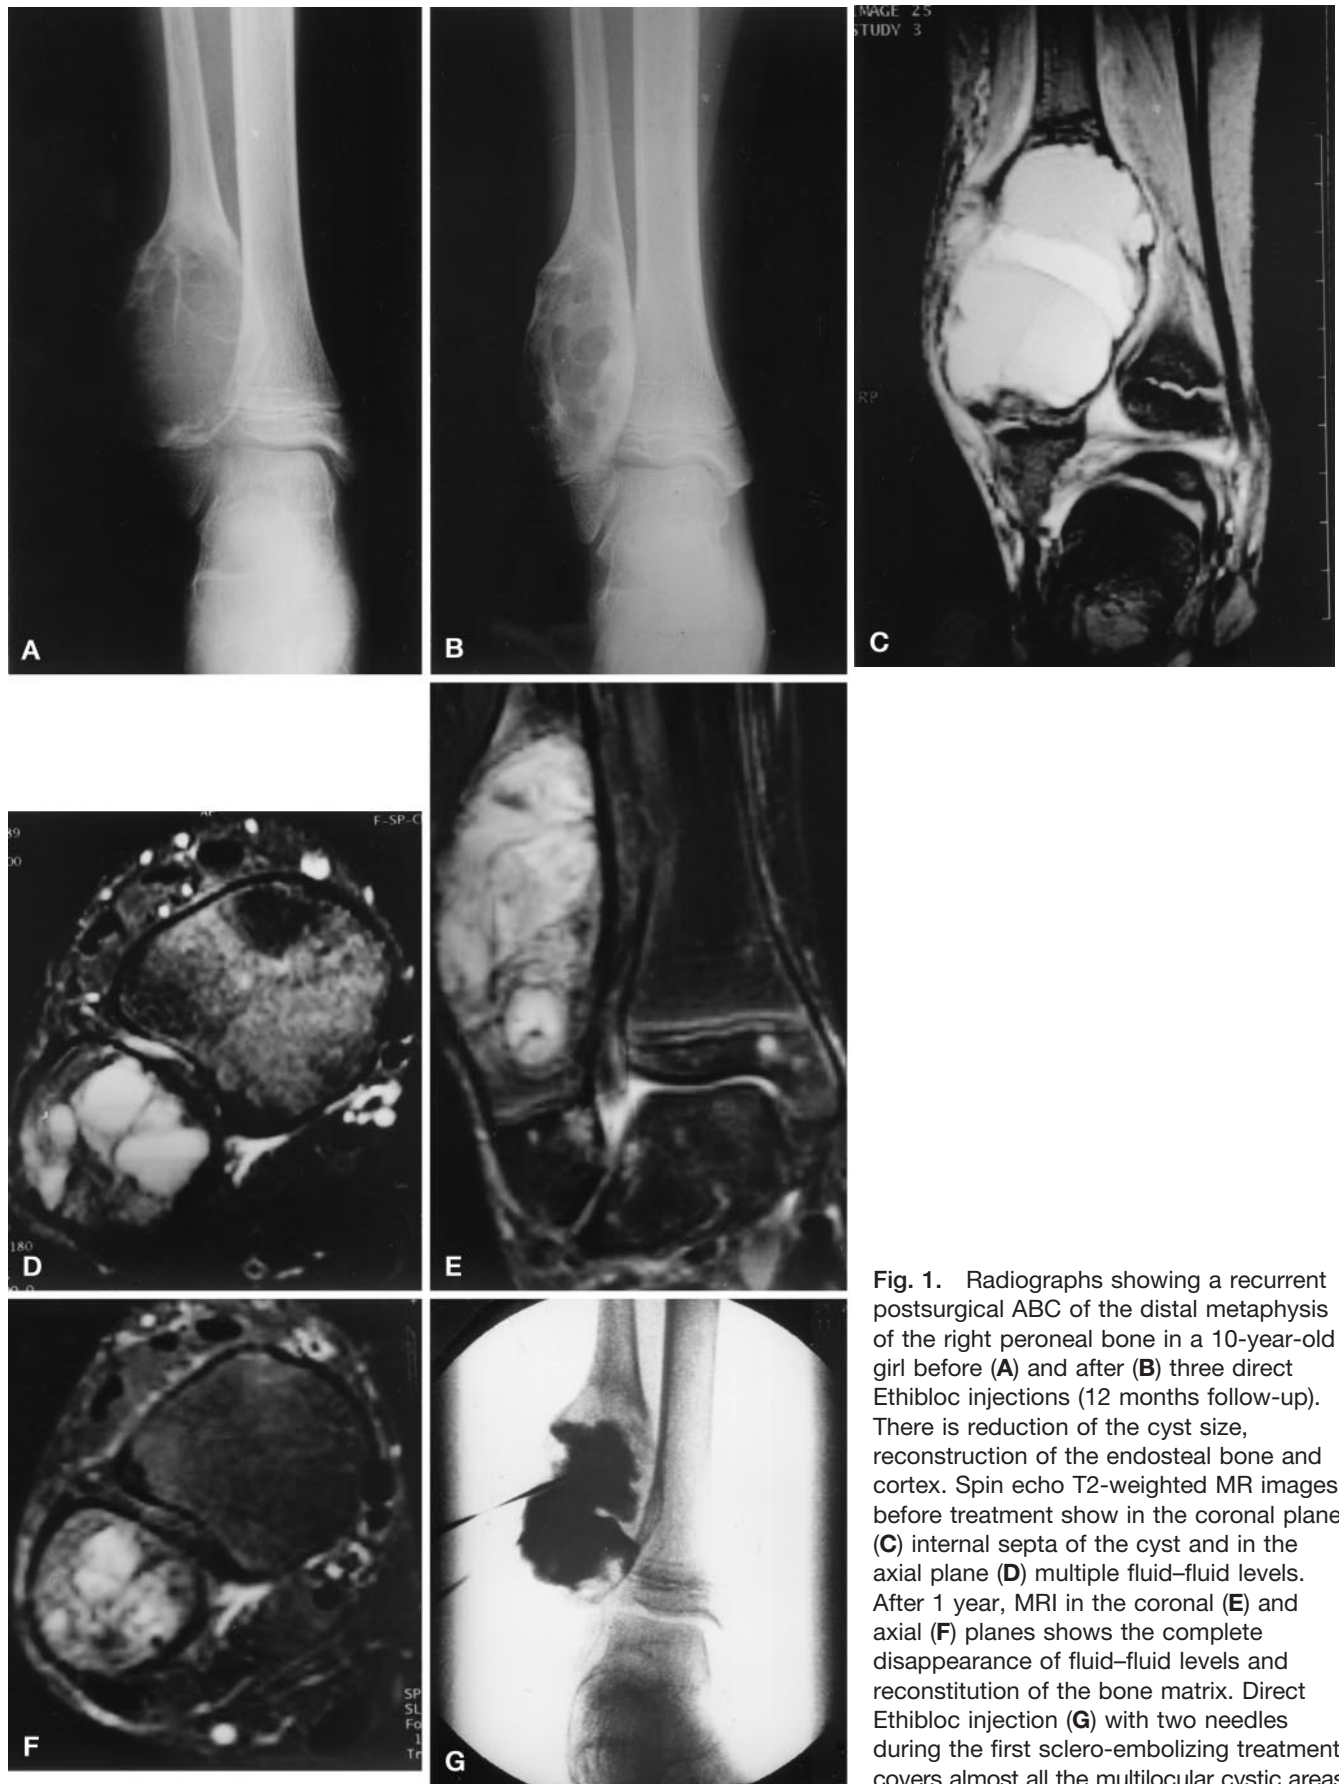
Radiographs showing a recurrent postsurgical ABC of the distal metaphysis of the right peroneal bone in a 10-year-old girl before (A) and after (B) three direct Ethibloc injections (12 months follow-up). There is reduction of the cyst size, reconstruction of the endosteal bone and cortex. Spin echo T2-weighted MR images before treatment show in the coronal plane (C) internal septa of the cyst and in the axial plane (D) multiple fluid–fluid levels. After 1 year, MRI in the coronal (E) and axial (F) planes shows the complete disappearance of fluid–fluid levels and reconstitution of the bone matrix. Direct Ethibloc injection (G) with two needles during the first sclero-embolizing treatment covers almost all the multilocular cystic areas.
